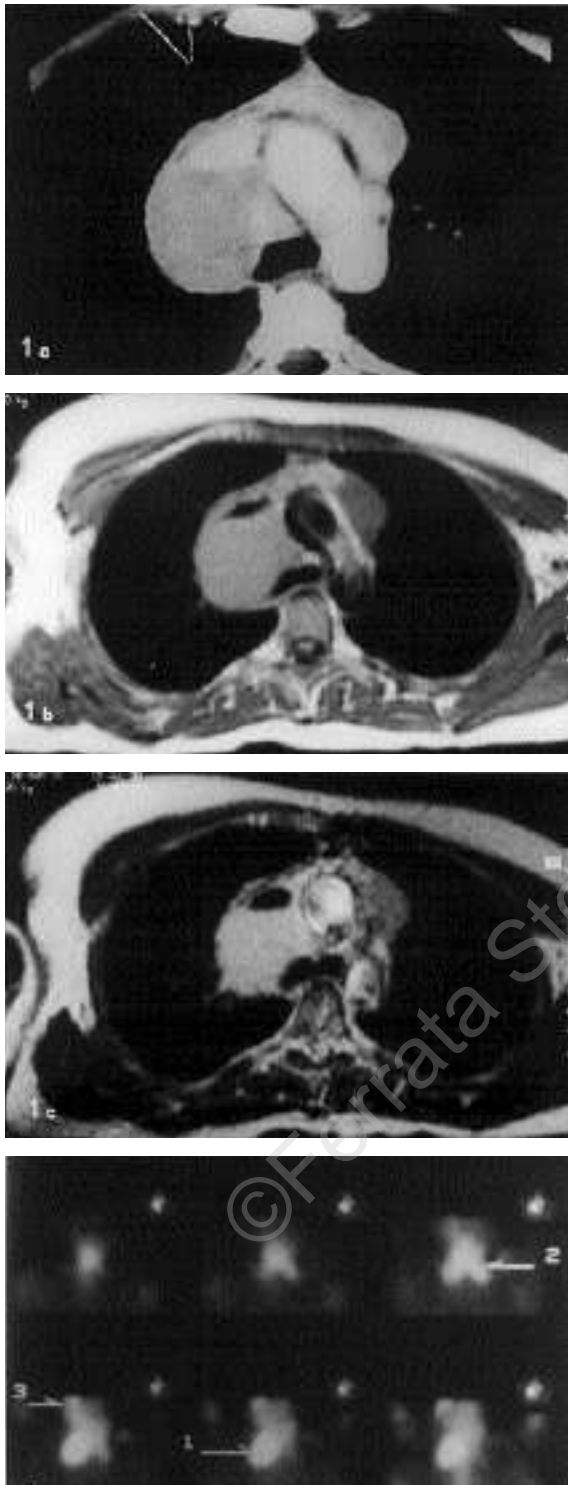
Case 1. Computed tomography (1a), magnetic resonance T1 (1b)-T2 (1c) and gallium 67 scintigraphy (1d) mediastinal images of lymphomatous involvement. The high intensity of the signal in T2 (1c) and gallium 67 uptake (1d) are consistent with the presence of metabolically active tumor cells.
